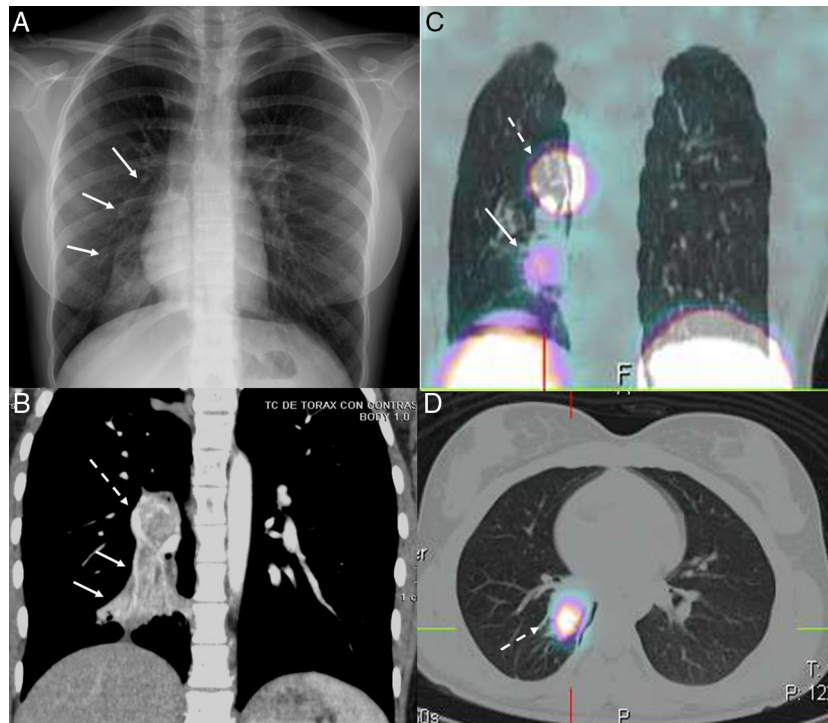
(A) Standard posteroanterior chest X-ray: right basal opacity with signs of atelectasis in right lower lobe (RLL) (arrows). (B) Coronal contrast-enhanced computed tomography (CT): right hilar mass (dotted arrow), enhanced after contrast administration, causing RLL atelectasis (solid arrow). (C) Chest SPECT-CT. Coronal slice: radiotracer hotspot in right hilar region, suggestive of neuroendocrine tumor (dotted arrow). Another less intense radiotracer uptake focus, below the hotspot, located in an area of pneumonitis with atelectasis (solid arrows). (D) Chest SPECT-CT. Axial slice: radiotracer hotspot located in right hilar mass (dotted arrow).
